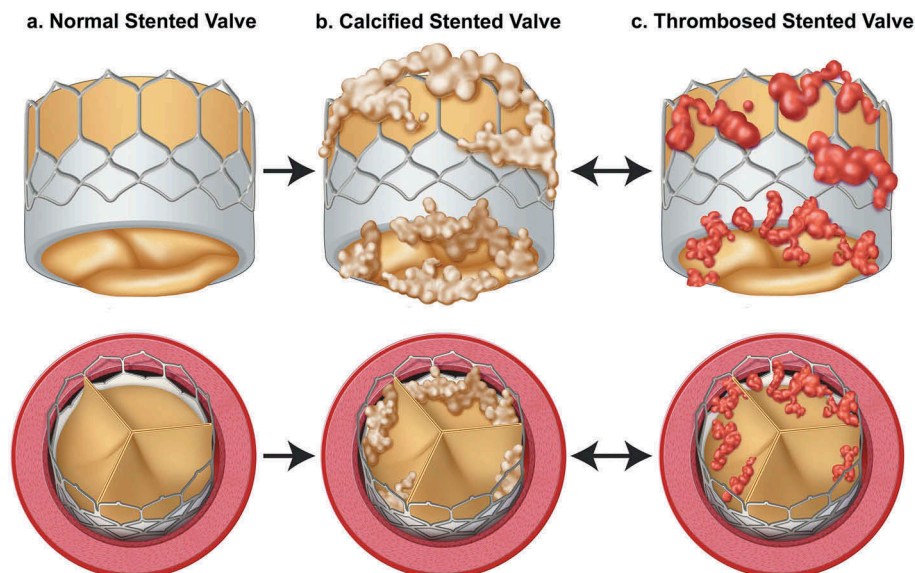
The phenotype of bioprosthetic valve deterioration with the development of calcification secondary to cardiovascular risk factors and subclinical thrombosis as detected by CT imaging.
